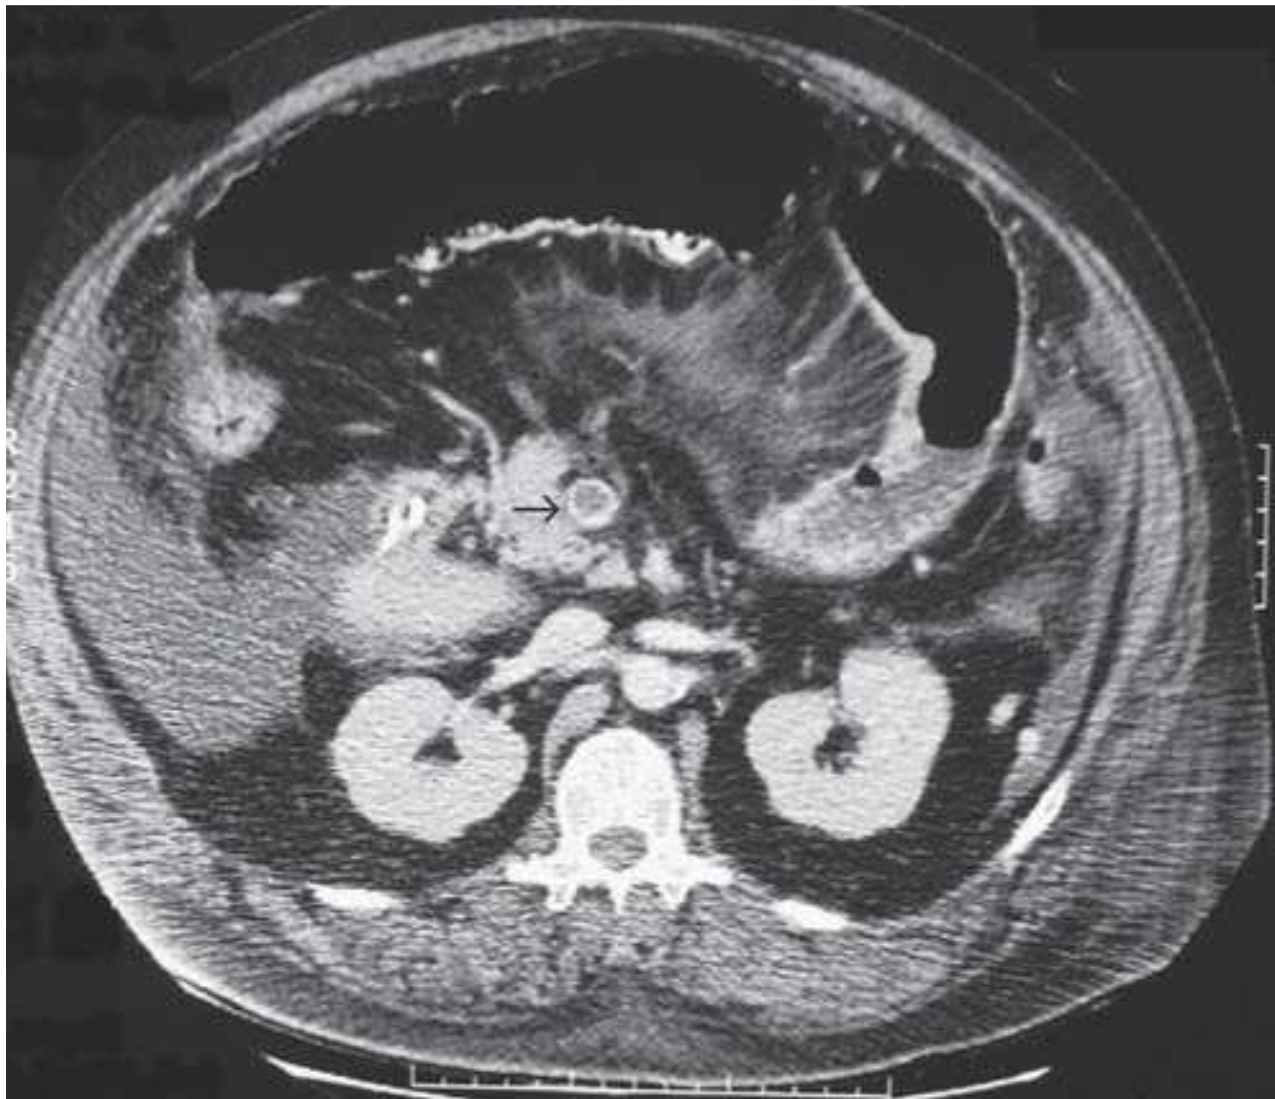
CT scan showing SMV thrombosis.
